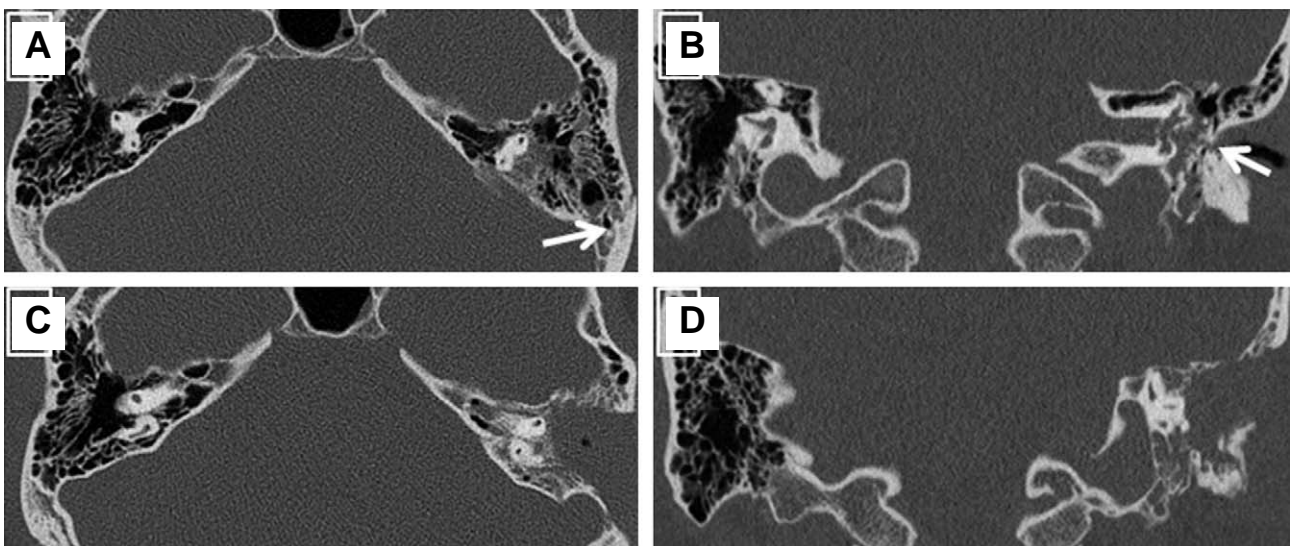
Preoperative (A, B) and postoperative (C, D) HRCT images of patient no. 3, transverse fracture line (white arrow) of the temporal bone in axial view of the left temporal bone (A) and coronal view (B), Transmastoid approach of axial view (C) and coronal view (D)
